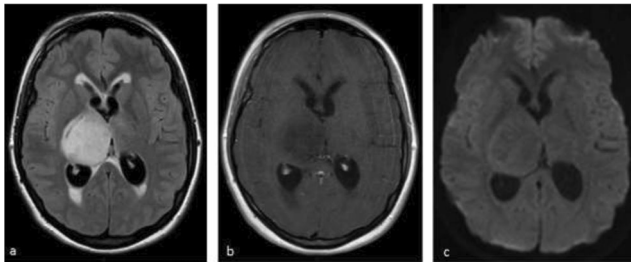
Thalamus lesion, Female patient, 15 years old. a) Axial FLAIR MRI image, b) Contrast-enhanced axial T1-weighted MRI image, c) Axial Diffusion-Weighted Image
